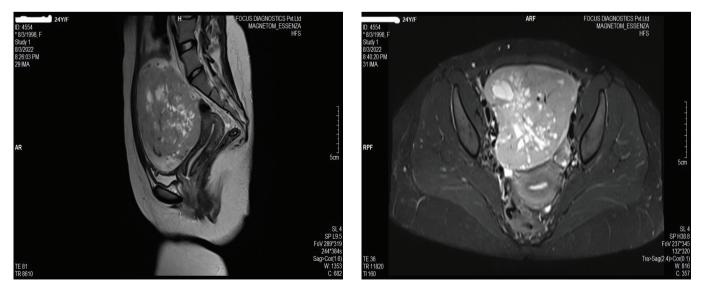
T2 weighted contrast enhanced MRI of the transverse and longitudinal section of the tumor at its maximum dimension. Reported as: Solid cystic lesion in right adenexa measuring 13 x 11 x 9.5 cm. With multiple tortuous draining venous channels noted along the lateral surface of the lesion.
